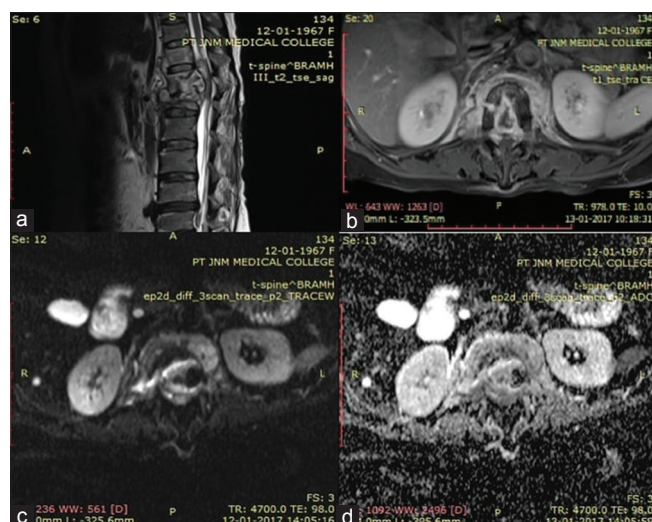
A 50-year-old female presented with bilateral paraplegia (a) sagittal T2-weighted imaging shows heterogeneous hyperintensity with collapse and associated paravertebral and epidural soft tissue component at T12 and L1 vertebrae. (b) Axial T1-weighted post contrast at the level of T12 and L1 vertebrae shows heterogeneous and peripheral enhancement. (c) Axial diffusion-weighted image at same level shows diffusion restriction in the vertebral body and soft tissue. (d) Corresponding axial apparent diffusion coefficient (ADC) map ($b = 0$ and 1000 s/mm^2 shows decreased signal intensity with an ADC value of 1.26 in bone and 1.55 in soft tissue component). [On culture, *Mycobacterium tuberculosis* was grown]
